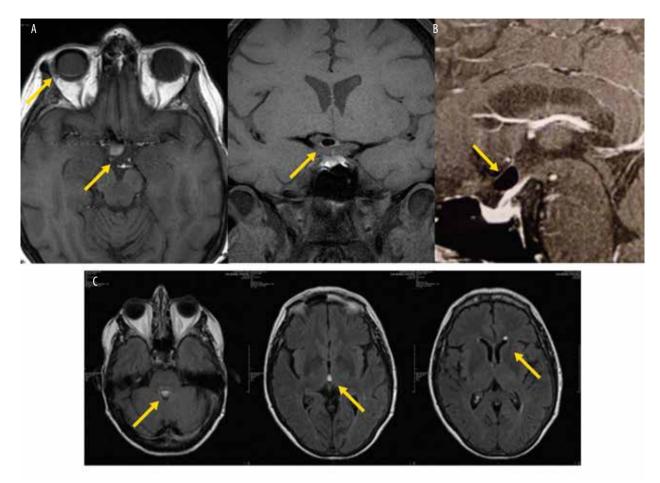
Brain MRI. (A) Axial T1-weighted image showing S0 in right vitreous cavity, optic nerve and chiasm. (B) Coronal and sagittal T1-weighted, fat suppressed and gadolinium images showing S0 inside the chiasm. (C) Axial T1-weighted images with the S0 in fourth, third and lateral ventricles. Arrows indicate the location of silicone oil.
